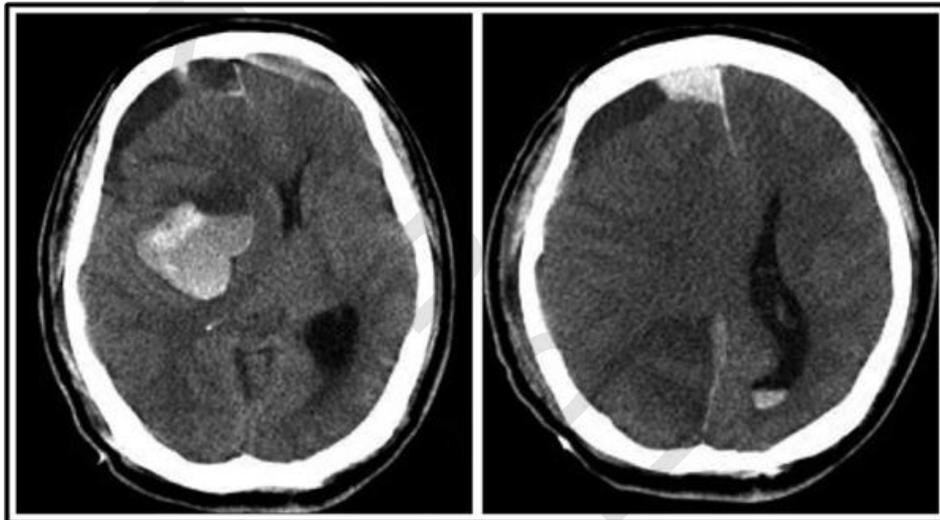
Postoperative computed tomography images showing intracerebral hemorrhage in right basal ganglia and subdural hematoma in right frontoparietal area after bur hole evacuation of CSDH.
